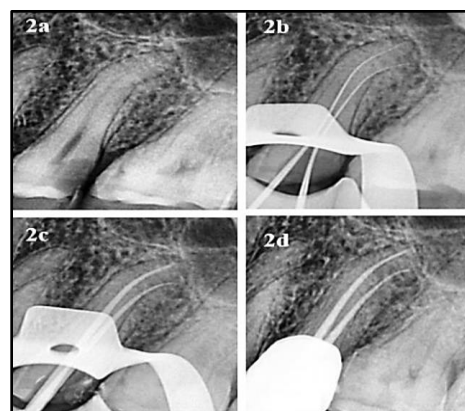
(a) Pre-operative radiograph working length (c) Master cone (d) Obturation
